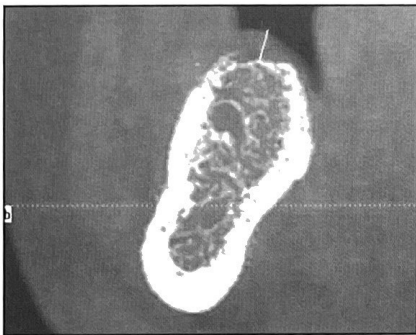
The blue line represents the vertical soft tissue measurement on the CBCT scan.
